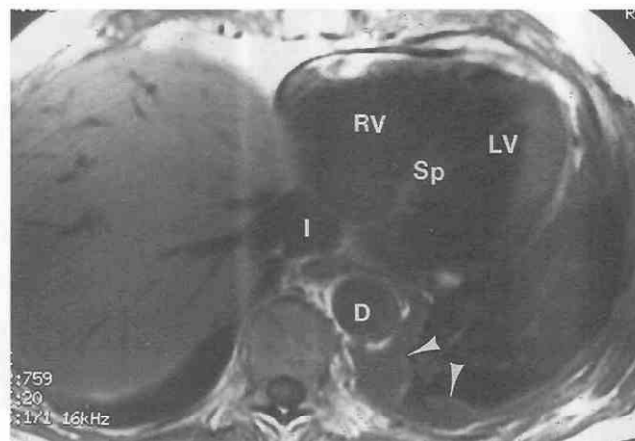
Axial MR image at the three-chamber level in a patient with mesothelioma of the left hemithorax. Loculated pleural fluid (arrowheads) can be seen in the left posterior hemithorax. D, descending aorta; I, inferior vena cava; LV, left ventricle; RV, right ventricle; Sp, intraventricular septum.
